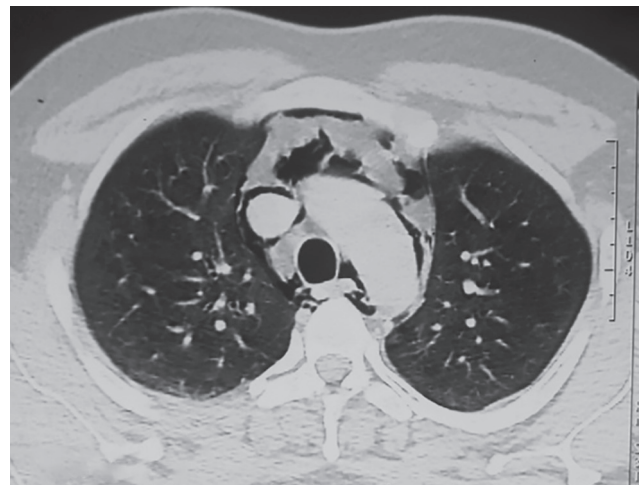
Axial section HRCT chest revealing pneumomediastinum with presence of air around main vessels
